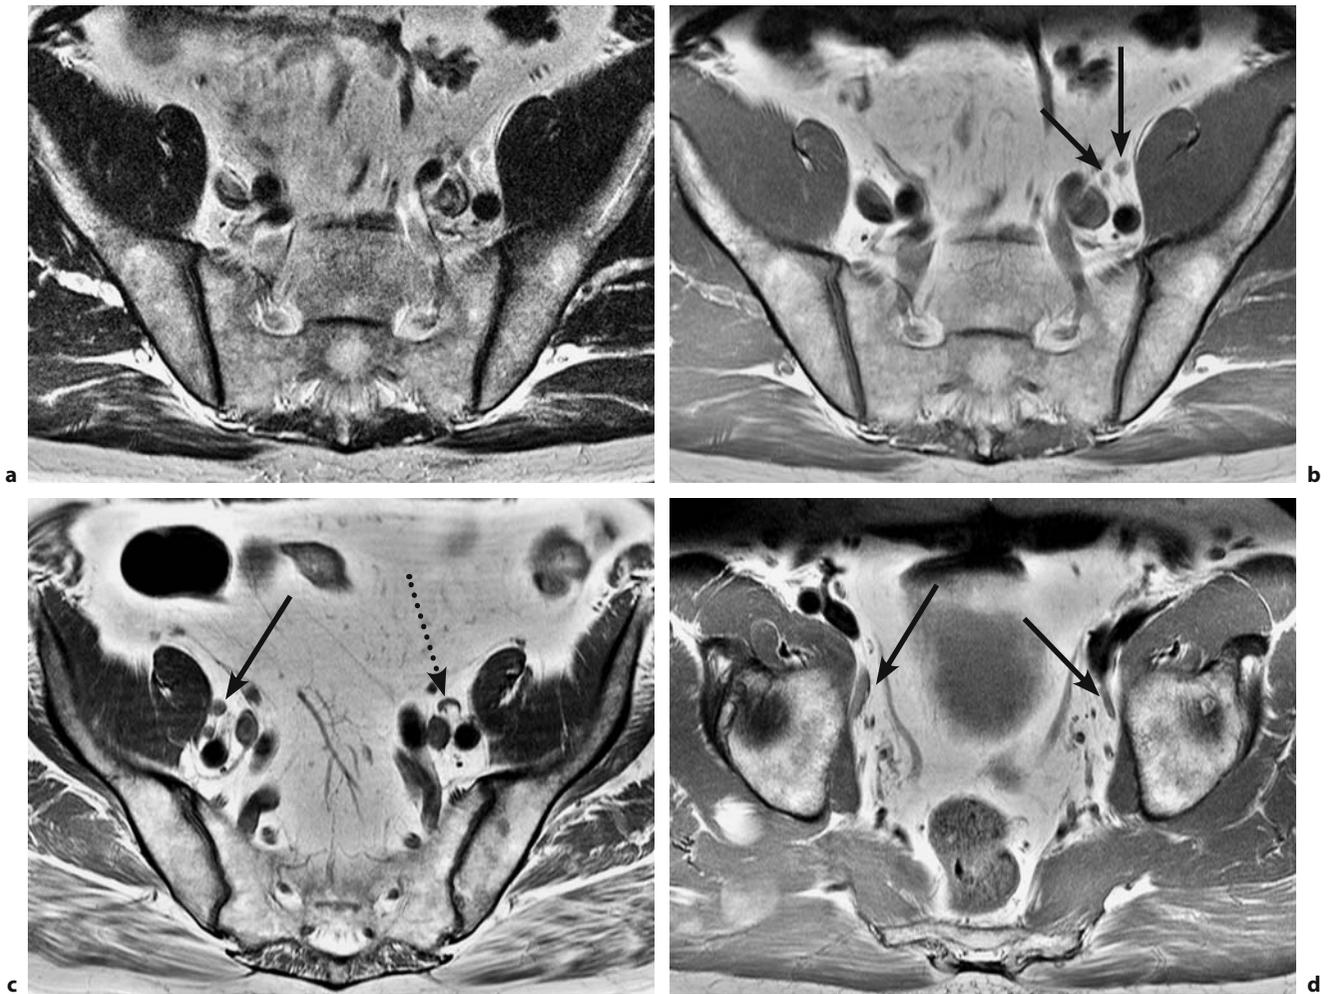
Normal pelvic lymph nodes. Axial MR images acquired with (a) T2w TSE sequence and (b–c) T1w TSE sequence at different levels (a and b are from the same level) (1.5 T). Small lymph nodes with a rounded appearance (a–c, *straight arrows* in b and c) are seen. They have low signal intensity on T1 and are nearly isointense to surrounding fat on T2. In addition, a lymph node on the left (*curved arrow*) is depicted with good visualization of the fatty hilus (fibrolipomatous degeneration, *dotted arrow* in c). Elongated lymph nodes on both sides at the pelvic wall (*arrows*, d)
